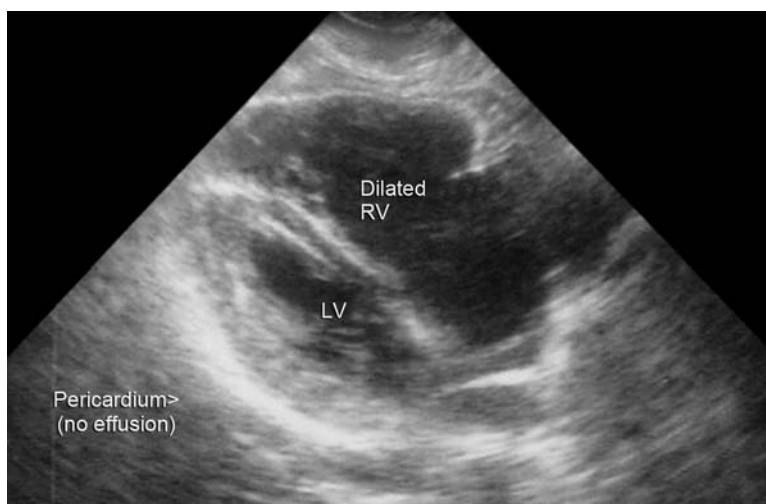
Ultrasound shows dilated RV
